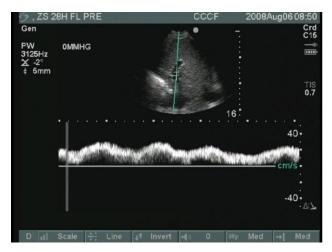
M-mode Ultrasound of Portal Vein Flow Velocity
